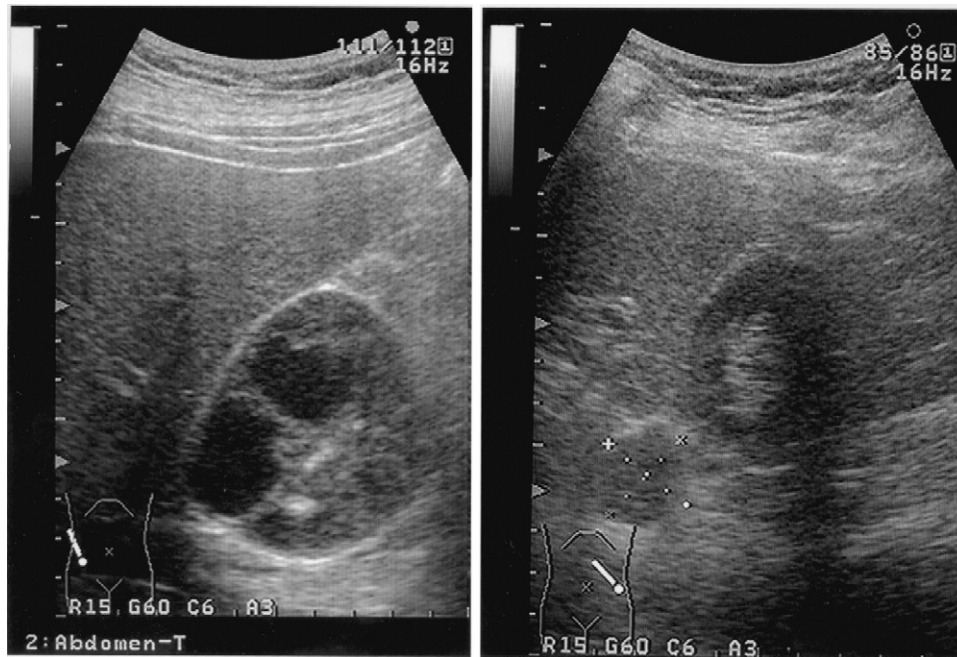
Ultrasonographic images of the abdomen showing a well-circumscribed hypoechoic mass with cystic components measuring 5.7×6.9 cm in diameter (left panel) and a well-circumscribed hypoechoic mass measuring 2.4×2.5 cm in diameter (right panel) located adjacent to the superior border of both kidneys.
